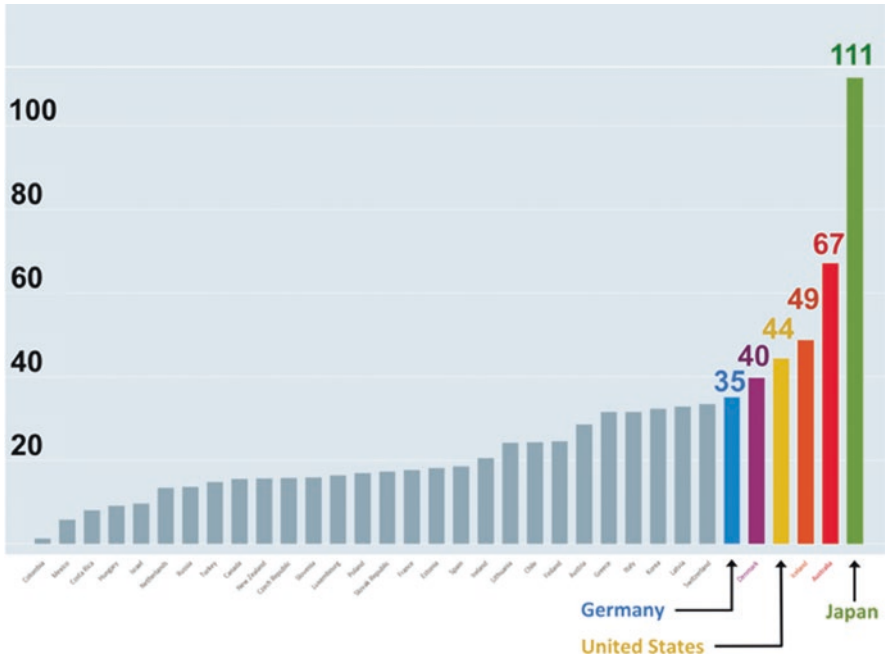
International comparison of total availability for computed tomography (CT) scanners, shown as CT scanners per one million inhabitants. Top 6 in quantitative order = Japan, Australia, Iceland, United States, Denmark and Germany (figure modified order = from <https://data.oecd.org>, 2018)
